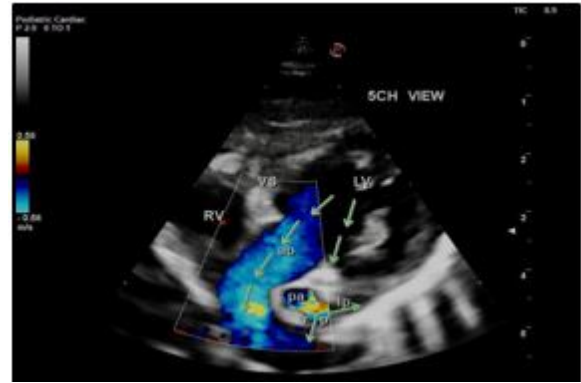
Apical 4CH view-Tricuspid atresia, large subaortic VSD, dilated LV, normal-sized RV. Horizontal arrows denote the presence of VSD, Oblique arrows denote Tricuspid atresia (TA).
